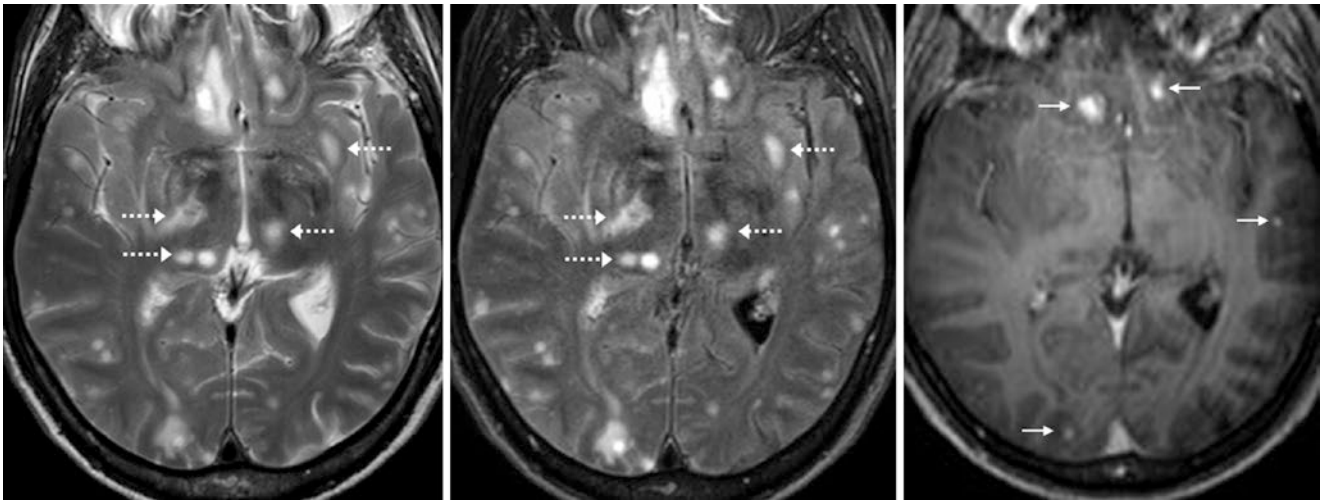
Comparison case of central nervous system toxoplasmosis. An immunocompromised 42 year old had numerous hyperintense lesions throughout the basal ganglia (*dotted arrows*) as well as throughout the subcortical white matter on a 3T MRI with axial T2WI (*left*) and FLAIR (*middle*). On postcontrast T1WI (*right*), some lesions enhanced (*thin arrows*)
